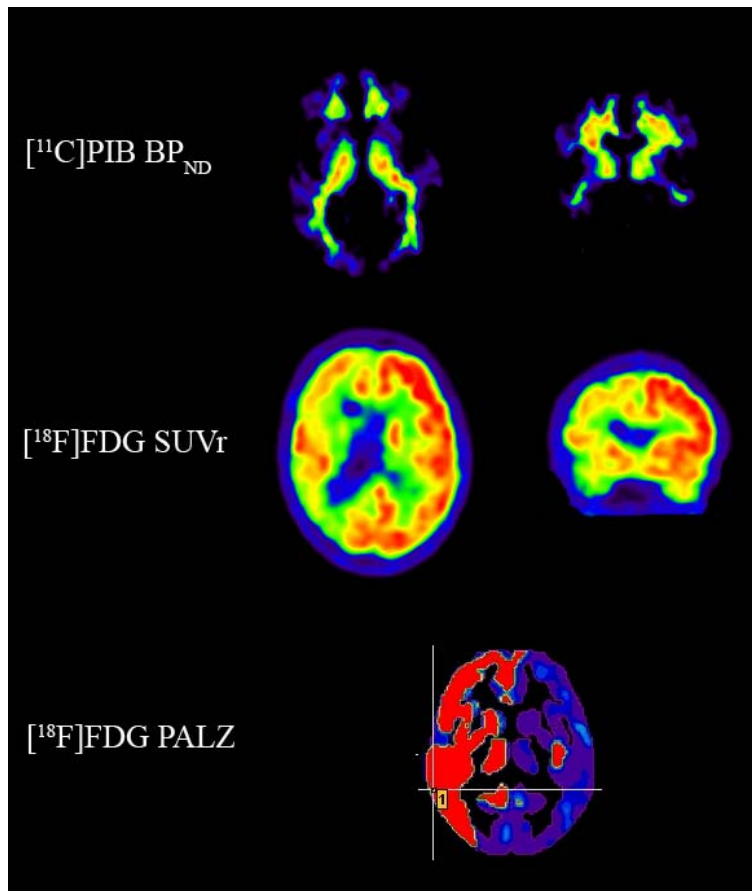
Example of a 59 year old male who visited the memory clinic for a second opinion. He presented with memory problems and spatial disorientation. This was confirmed by his spouse who also mentioned several behavioural problems like aggression and apathy. Neuropsychological testing revealed visuo-spatial disturbances, memory deficits and low MMSE (22) and CAMCOG (80) scores. Fronto-temporo-parietal brain atrophy was observed on MRI, most pronounced in the right hemisphere. Differential diagnosis after the multidisciplinary consensus meeting consisted of 1) atypical Alzheimer's disease (AD), 2) corticobasal degeneration (CBD), or 3) behavioural variant frontotemporal dementia. For this study, the probability diagnosis was set to AD with a diagnostic certainty of 50%. [^{11}C]PIB PET showed predominantly white matter binding and the diagnosis of AD is therefore highly unlikely. [^{18}F]FDG PET displayed extremely asymmetric metabolic impairment in the right hemisphere with involvement of the basal ganglia. This pattern is suggestive for CBD. According to these PET findings, the clinician changed the diagnosis to CBD with a diagnostic certainty of 90%. Two-year follow-up revealed cognitive deterioration (MMSE declined to 12), further progression of brain atrophy and a disease course that fits the diagnosis of CBD.
